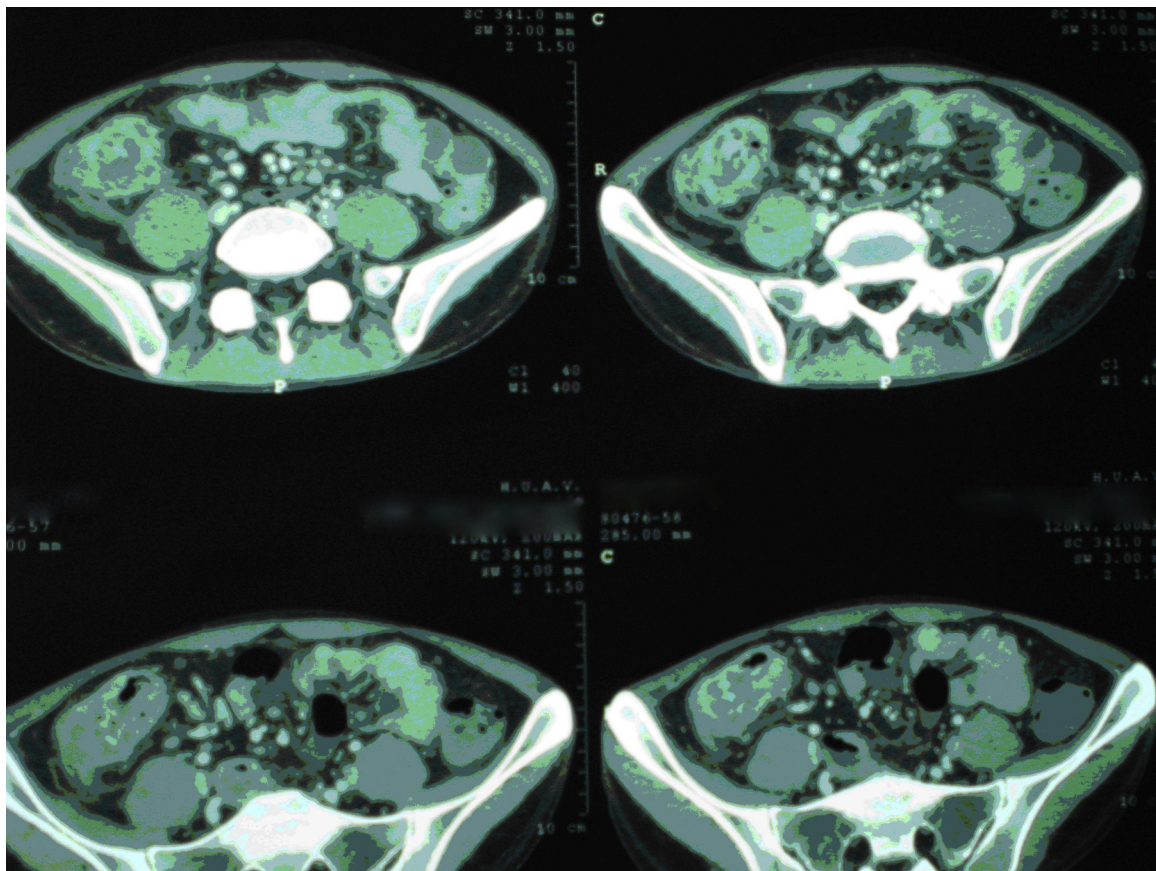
Abdominal CT-scan that displays moderate ascites, mesenteric lymphadenopathy, and diffuse small bowel and colonic wall thickening concentrating in the cecum.
